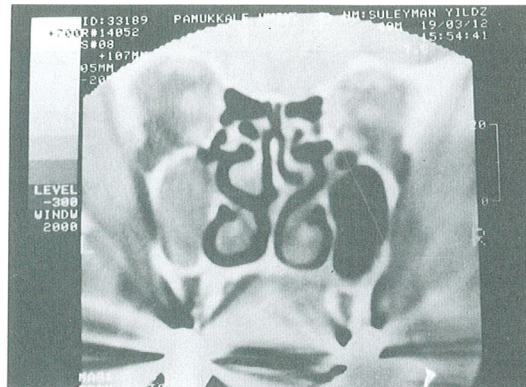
Coronal CT scan showing a soft tissue mass filling in the left maxillary sinus antrum.
